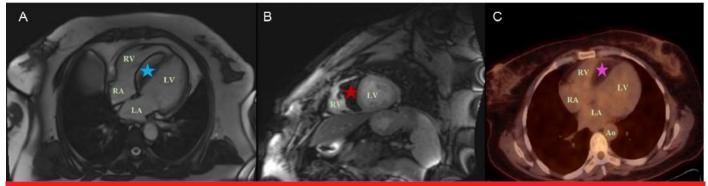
Cardiac MRI images showing a mass lesion along the right border of the interventricular septum, measuring $65 \times 60 \times 25$ mm and extending from the base toward the apex. A) bSSFP sequence reveals peripheral chemical shift artifact indicating fat content. B) Fat-suppressed T2-weighted image shows the lesion as hypointense due to effective fat suppression. The mass protrudes into and narrows the right ventricular cavity. C) Whole-body PET scan (thoracic transverse section) showing a 2 cm hypodense thickening at the interventricular septum without pathological FDG uptake.
